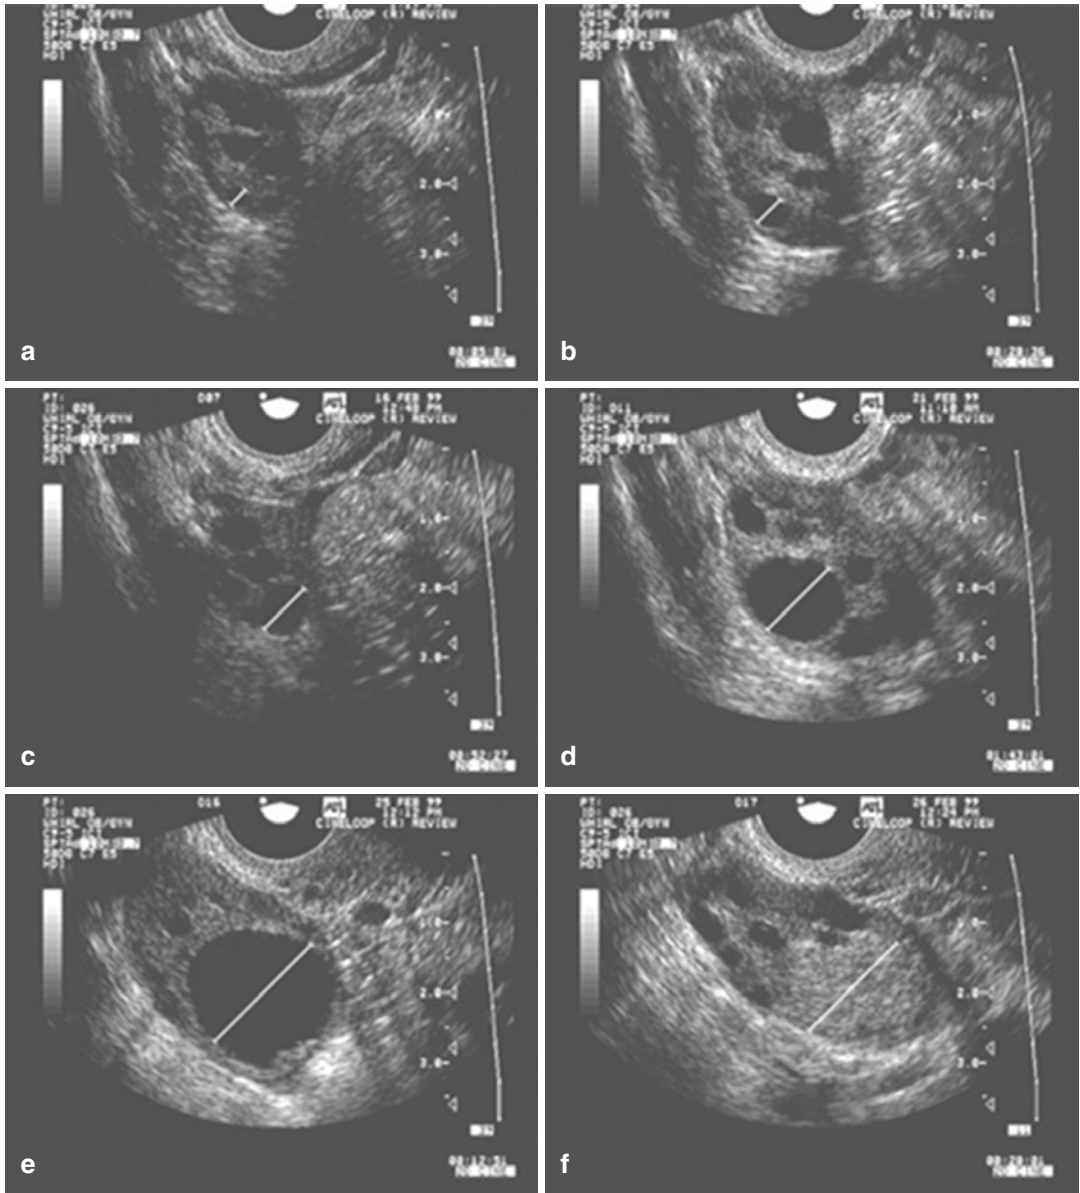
Serial transvaginal ultrasonographic images of the right ovary of a research participant on days 1 (a), 4 (b), 7 (c), 11 (d), 16 (e), and 17 (f) of a spontaneous menstrual cycle. The same ovarian follicle is identified throughout the growth phase in (a)–f. The corresponding
